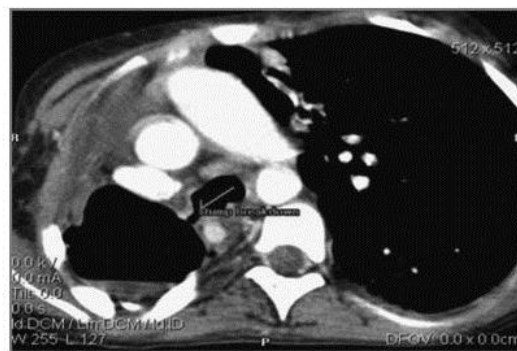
Post contrast CT scan demonstrates the area of stump breakdown, just distal to the carina, which communicates with an air-containing right hemithorax. Note also the presence of an air-fluid level. The mediastinum is displaced towards the side of the pneumonectomy.
